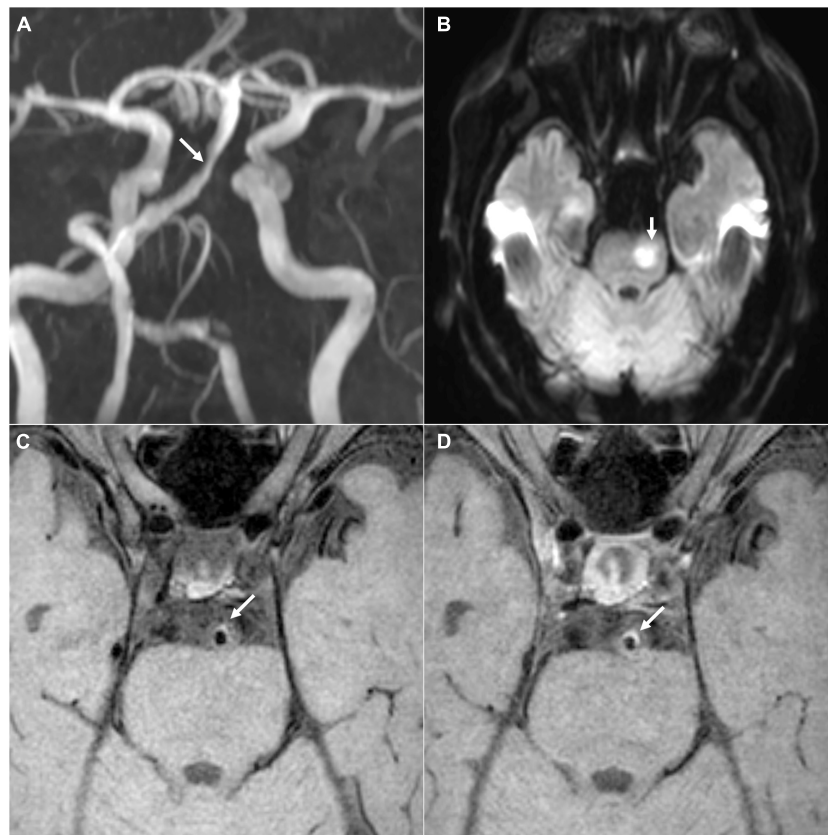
A representative case of acute ischemia in vertebrobasilar circulation. (A) The MRA image shows stenosis in the BA (white arrow). (B) The diffusion-weighted image shows acute infarction in the BA territory (white arrow). (C,D) The pre- and post-contrast T1-weighted images show the BA plaque as a symptomatic lesion, respectively (white arrows). BA, basilar artery; MRA, magnetic resonance angiography.
